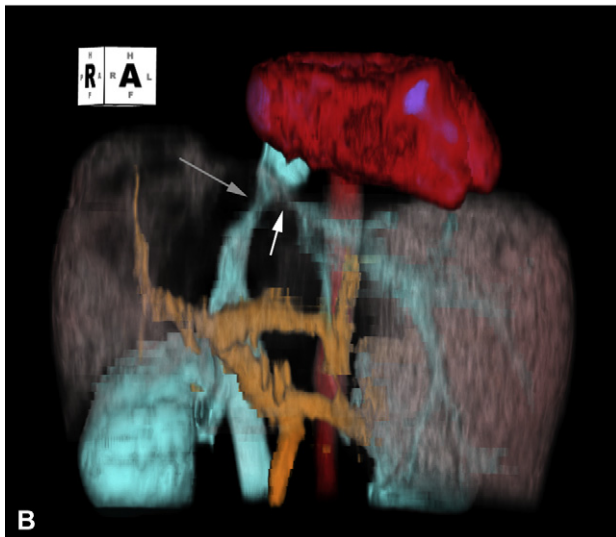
Preoperative magnetic resonance images. (A) Tumor occupies mainly the right hemiliver and part of the left medial section. Note that left hepatic vein is invaded by tumor at its insertion to inferior vena cava (arrow). (B) Three-dimensional reconstruction image shows narrowing of retrohepatic vena cava (long and gray arrow) and left hepatic vein (short and white arrow). Right and middle hepatic veins are not visualized from the obliteration by tumor.
